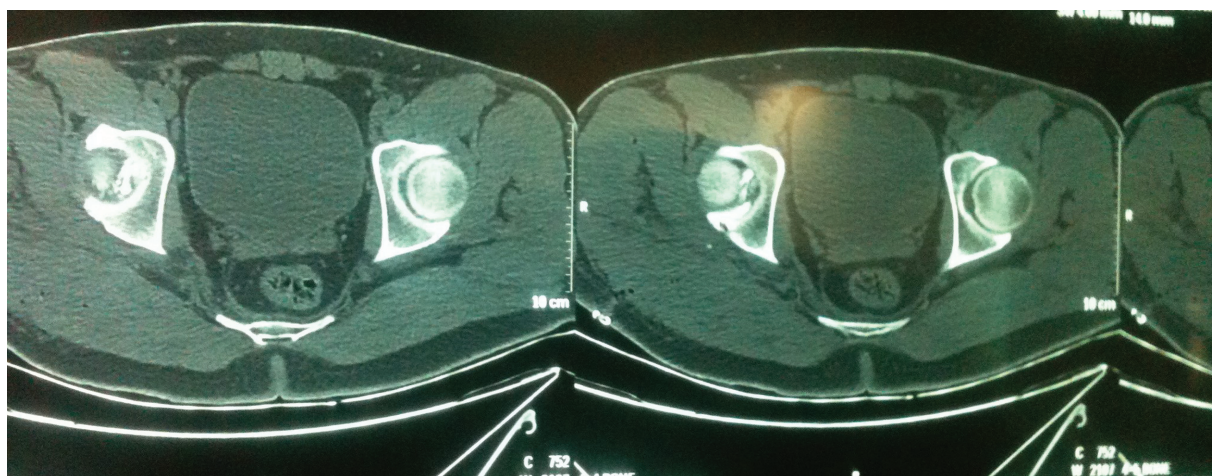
Axial images of the preoperative computed tomography (CT) scan of the affected hip after reduction.
